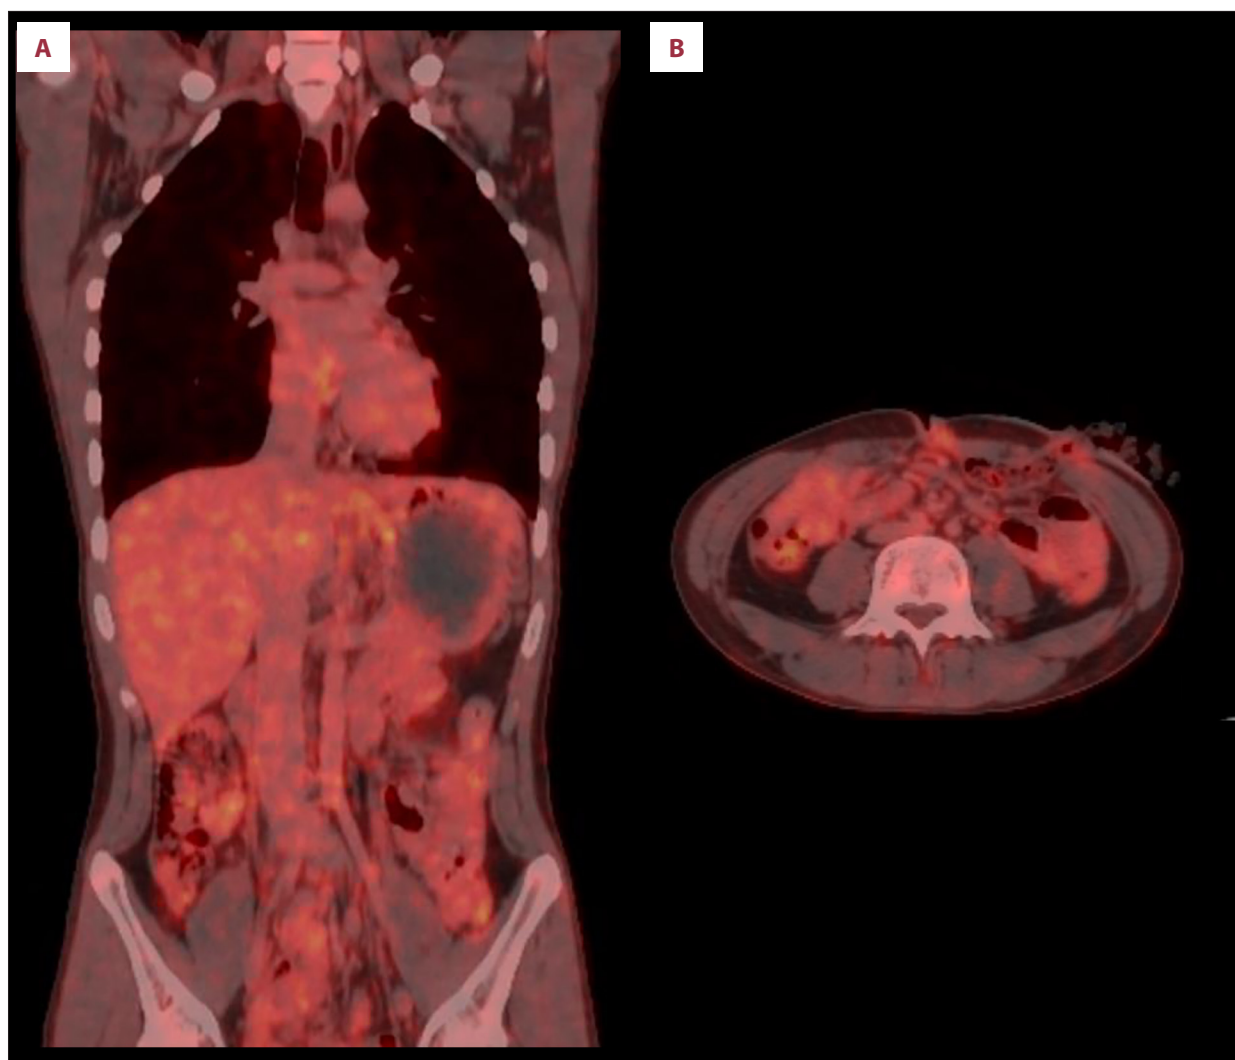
Positron emission tomography/computed tomography (PET/CT). (A) PET/CT demonstrating no abnormal hypermetabolic activity suggestive of distant metastatic disease. (B) Metabolically inactive left adrenal lesion (arrow), consistent with a benign adrenal adenoma.
